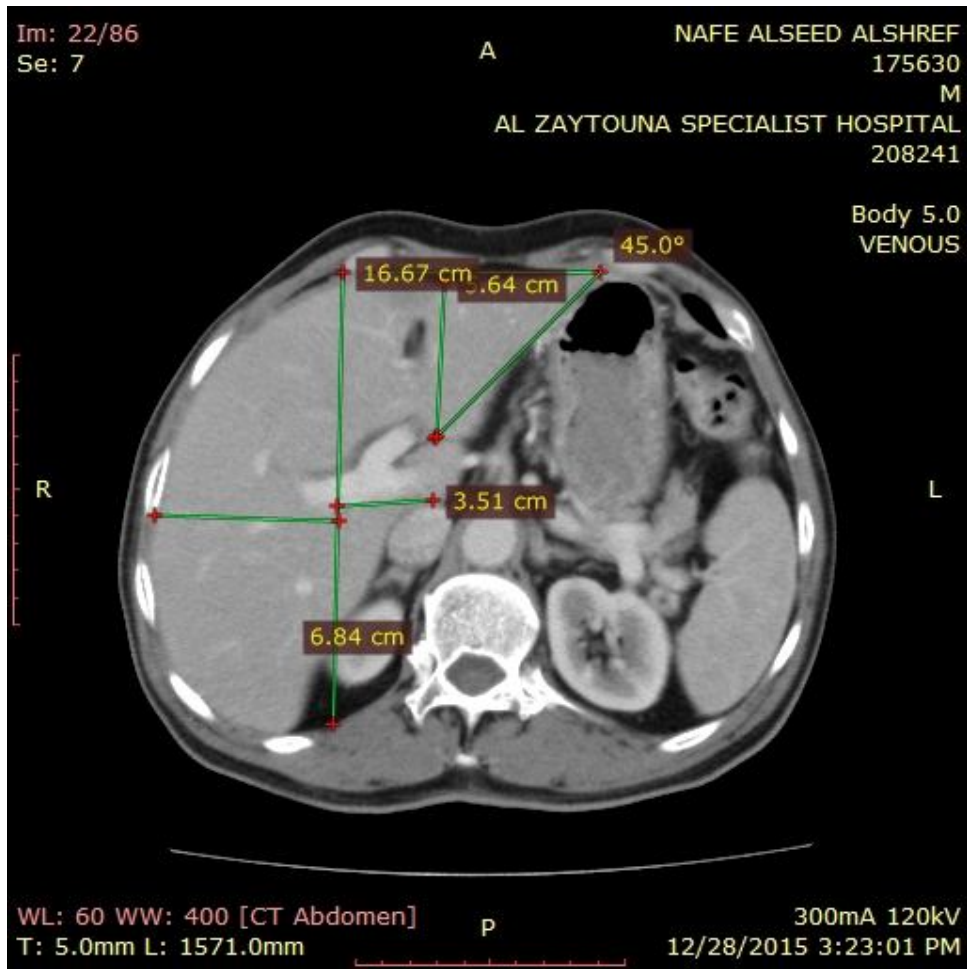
Fig CT liver axial venous phase the left hepatic angle- 45.0° AP diameter of the left hepatic lobe -5.64 cm diameter of the right lobe -6.84 cm diameter of the caudate lobe-3.51 cm
